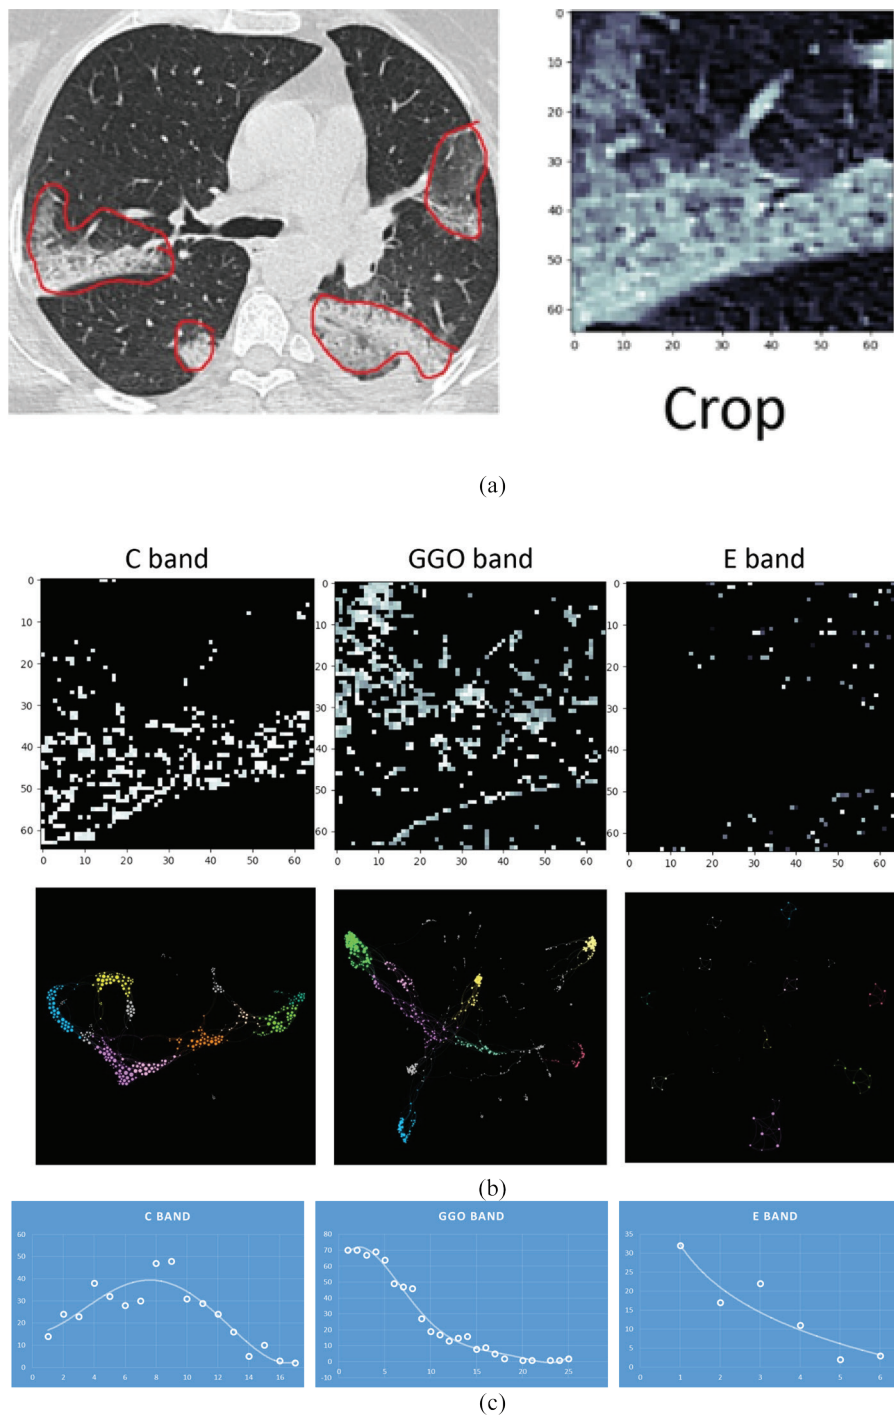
Axial HRCT Organising Pneumonia(OP) patient – (a) relevant slice (b) CN on all three bands (c) Degree distribution plots (lesion intensity).
